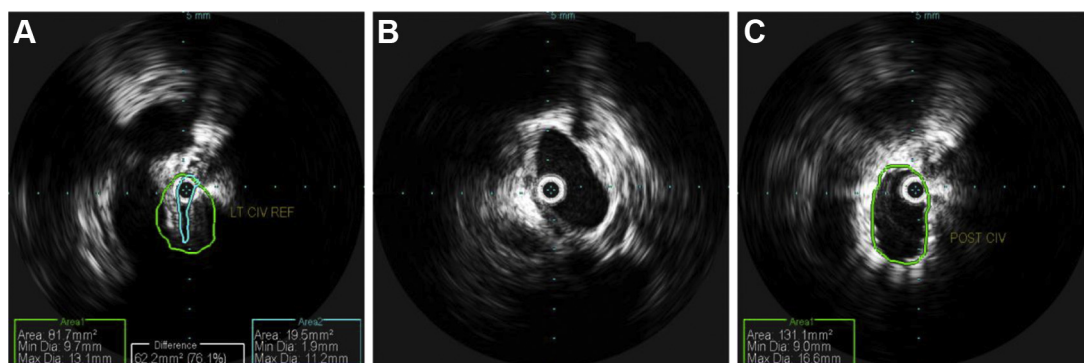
(A) An intravascular ultrasound examination was performed revealing near complete occlusion of the left common iliac vein with external compression by the right iliac common iliac artery. Left common iliac vein with associated area and diameter of vessel and open lumen. (B) Postintervention intraoperative image of intravascular ultrasound examination demonstrating patent inferior vena cava (IVC) without evidence of thrombus. (C) Postintervention intraoperative image of intravascular ultrasound imaging demonstrating the left common iliac vein with associated area and diameter of vessel and open lumen significantly increased in size after thrombectomy.
